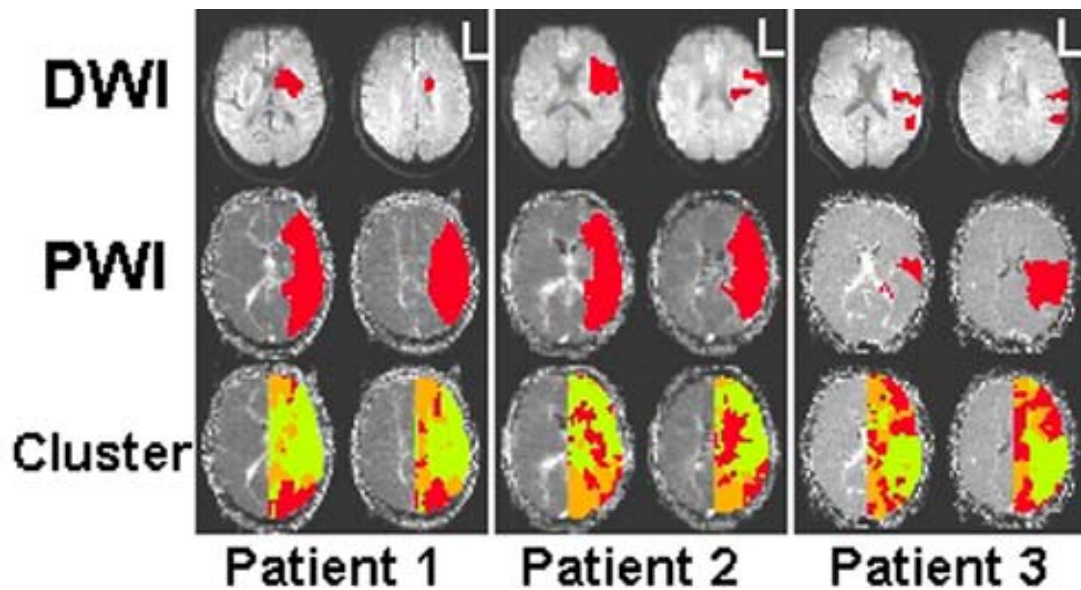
The three-cluster results of the disturbed hemisphere for three patients (Cluster). Light green cluster almost covered the disturbed areas including the infarct core (DWI) and hypoperfusion area (MTT map from PWI).
